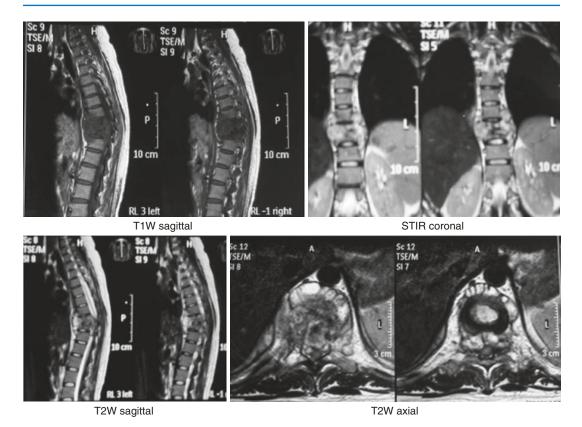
MRI showing body destruction, paravertebral abscesses, spinal cord condition, and location of great vessels
